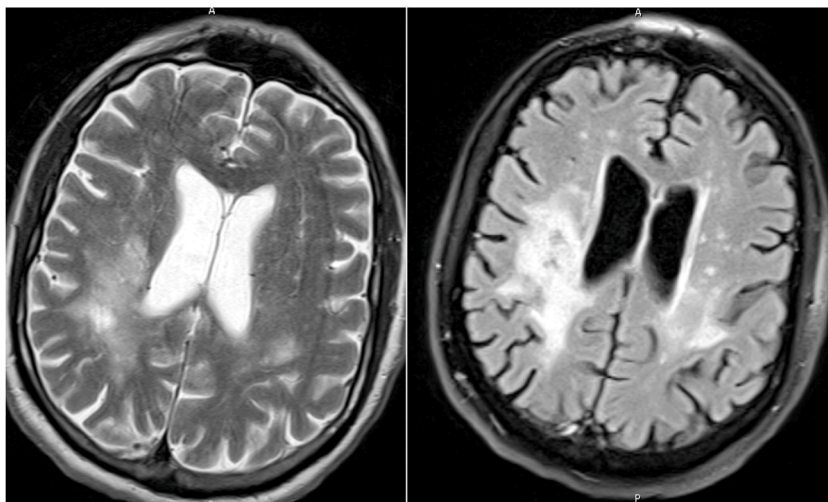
Initial Brain MRI In Our Patient Supporting Diagnosis of PML T2 FLAIR
